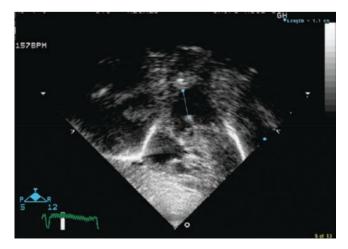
2D echocardiogram. Subcostal view of a large proximal (type 1) AP window
